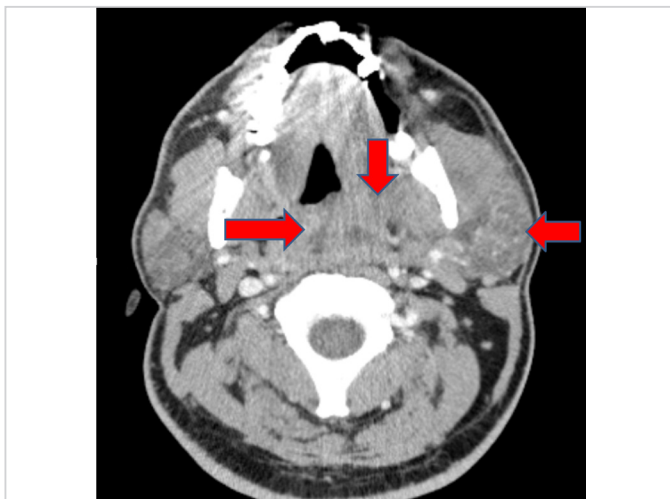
Neck CT image showing peritonsillar-parapharyngeal-intraparotid multifocal abscess areas (arrows)
